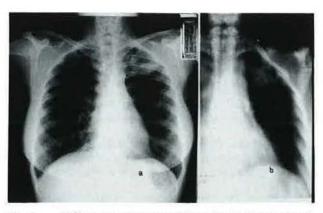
a) Chest roentgenogram of the patient before treatment. b) Tomographic detail of left upper lobe solitary nodule.
